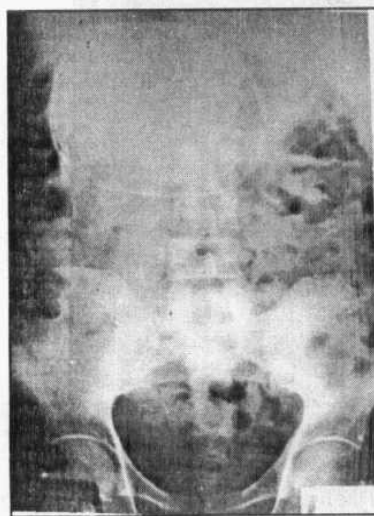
plain x-Ray abdomen showed calcified wall of hydatid cyst.
